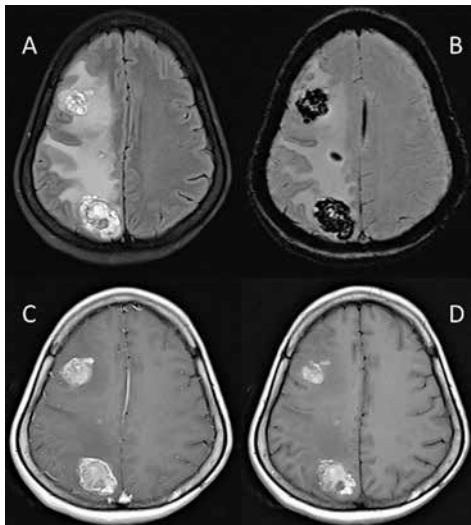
Magnetic resonance imaging of the brain with contrast showing multiple T2 heterogeneous intensity lesions in the right hemisphere with a midline shift towards the left. The lesions have moderate perilesional oedema with blooming on SWI (B) and hyperintense appearance on T1 (D), suggestive of haemorrhagic metastases.
